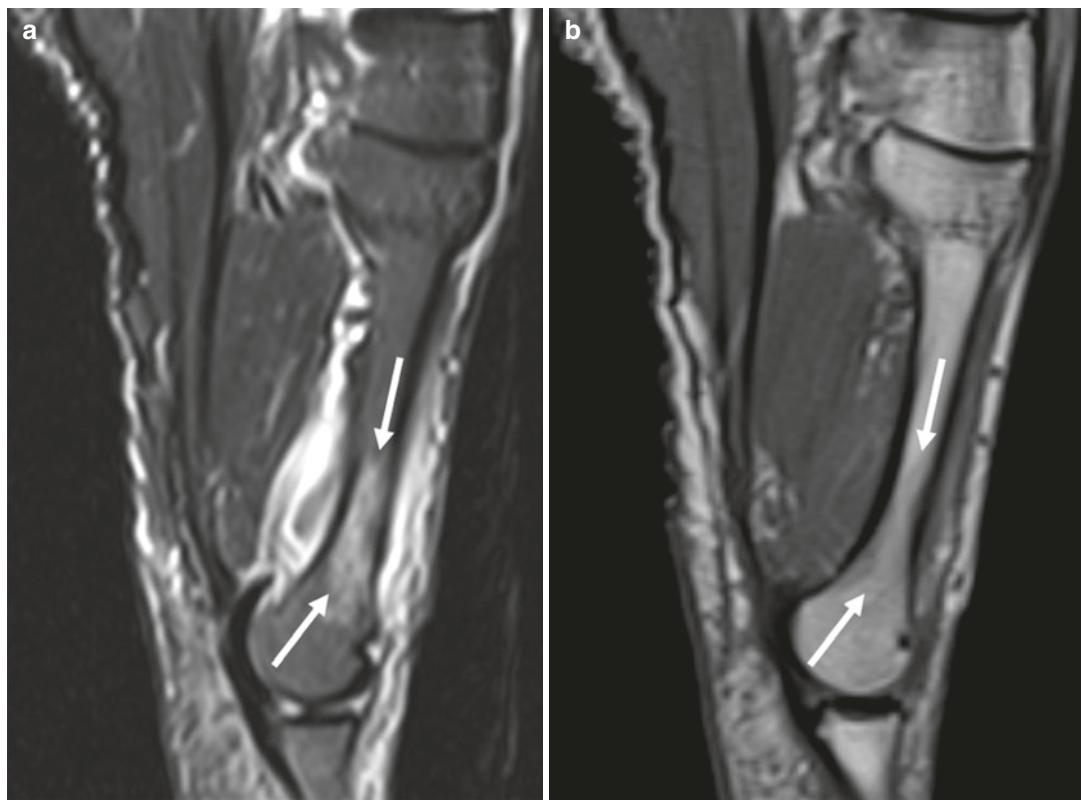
Forty-two-year-old woman runner with increasing right foot pain at the distal second metatarsal. Radiographs are normal. Sagittal STIR (a) and T1-weighted
